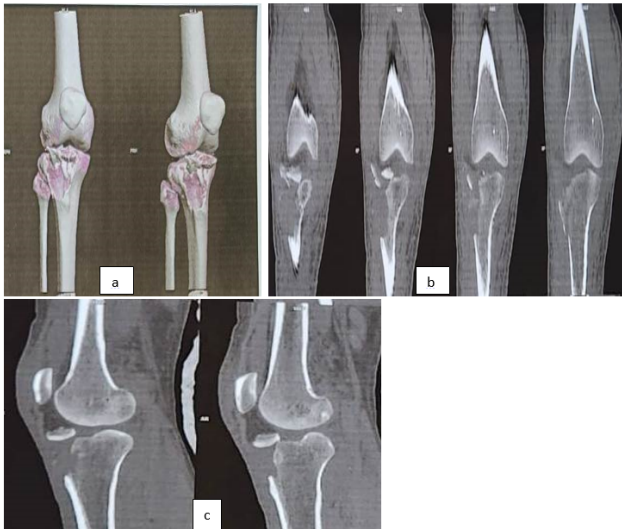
a): The computed tomography scan (b): Coronal section and c): Sagittal section) study demonstrates the tibial tubercle fracture
